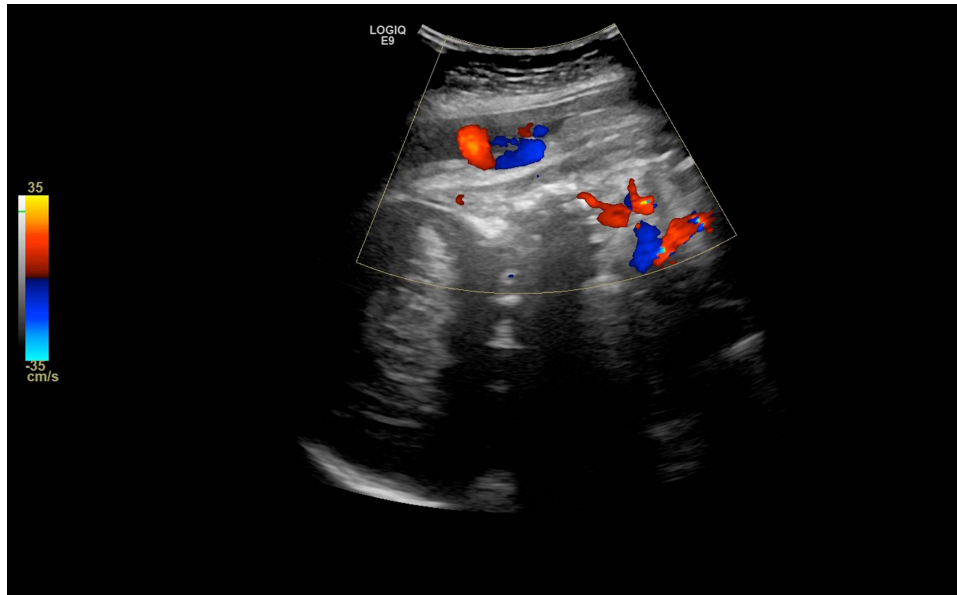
Routine obstetric ultrasound examination I.
